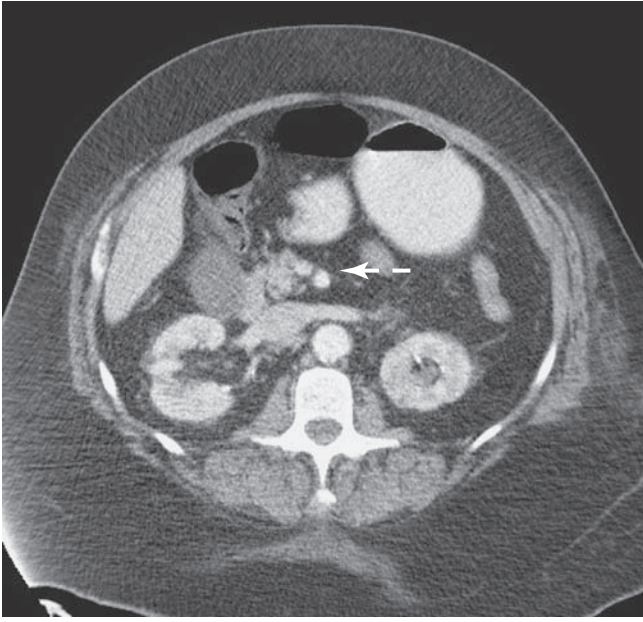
CT Scan of superior mesenteric artery (SMA) embolus showing patent SMA (*right*) with more distal thrombosis (*left*).
